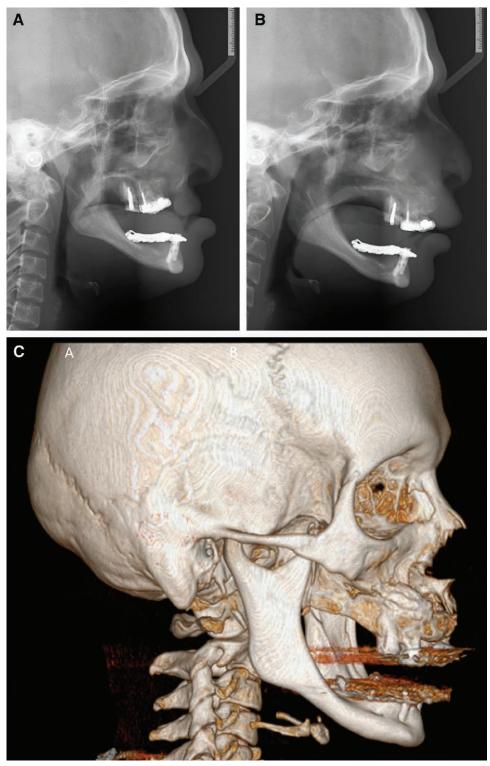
Radiographs demonstrating the extensive maxillary movement. A, Preoperative lateral cephalogram demonstrates the retrognathic position of the maxilla resulting in a concave profile and edentulous aged appearance. B, The achieved facial convexity and sagittal maxillary advancement are presented in the postoperative lateral cephalogram. C, Three-dimensional computerized tomography demonstrates the newly formed maxillary bone resulting in normal intermaxillary relations.
